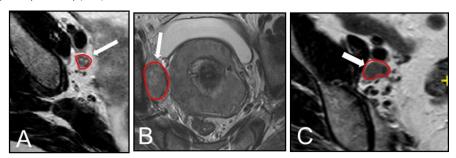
Three examples of GTV-N selection and delineation on T2W FSE MRI. (A) Small lymph node which is not suspicious based on dimension (<1 cm short axis); however, it has irregular border and high, inhomogeneous signal. It was also PET positive. (B) Large hyperintense inhomogeneous and irregular metastatic lymph node. (C) Medium sized (>1 cm) metastatic lymph node with irregular border and intermediate signal intensity.
